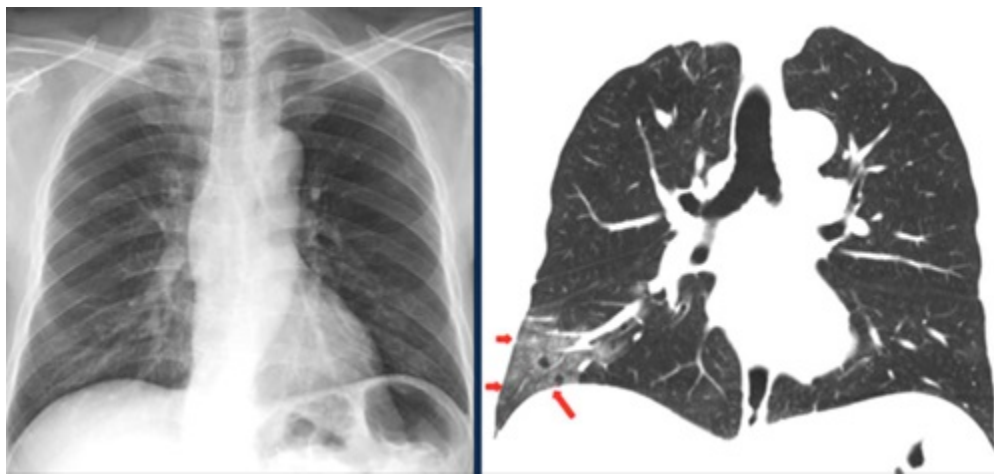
Thorax CT is more sensitive than chest x-ray in imaging lesions. In thorax CT, ground glass opacities in the lower right lobe are not noticed on the simultaneous radiograph (red arrow).
